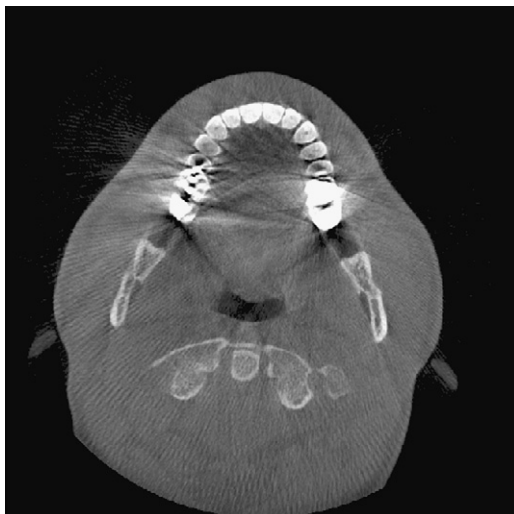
Dental restoration artifact in CBCT.
